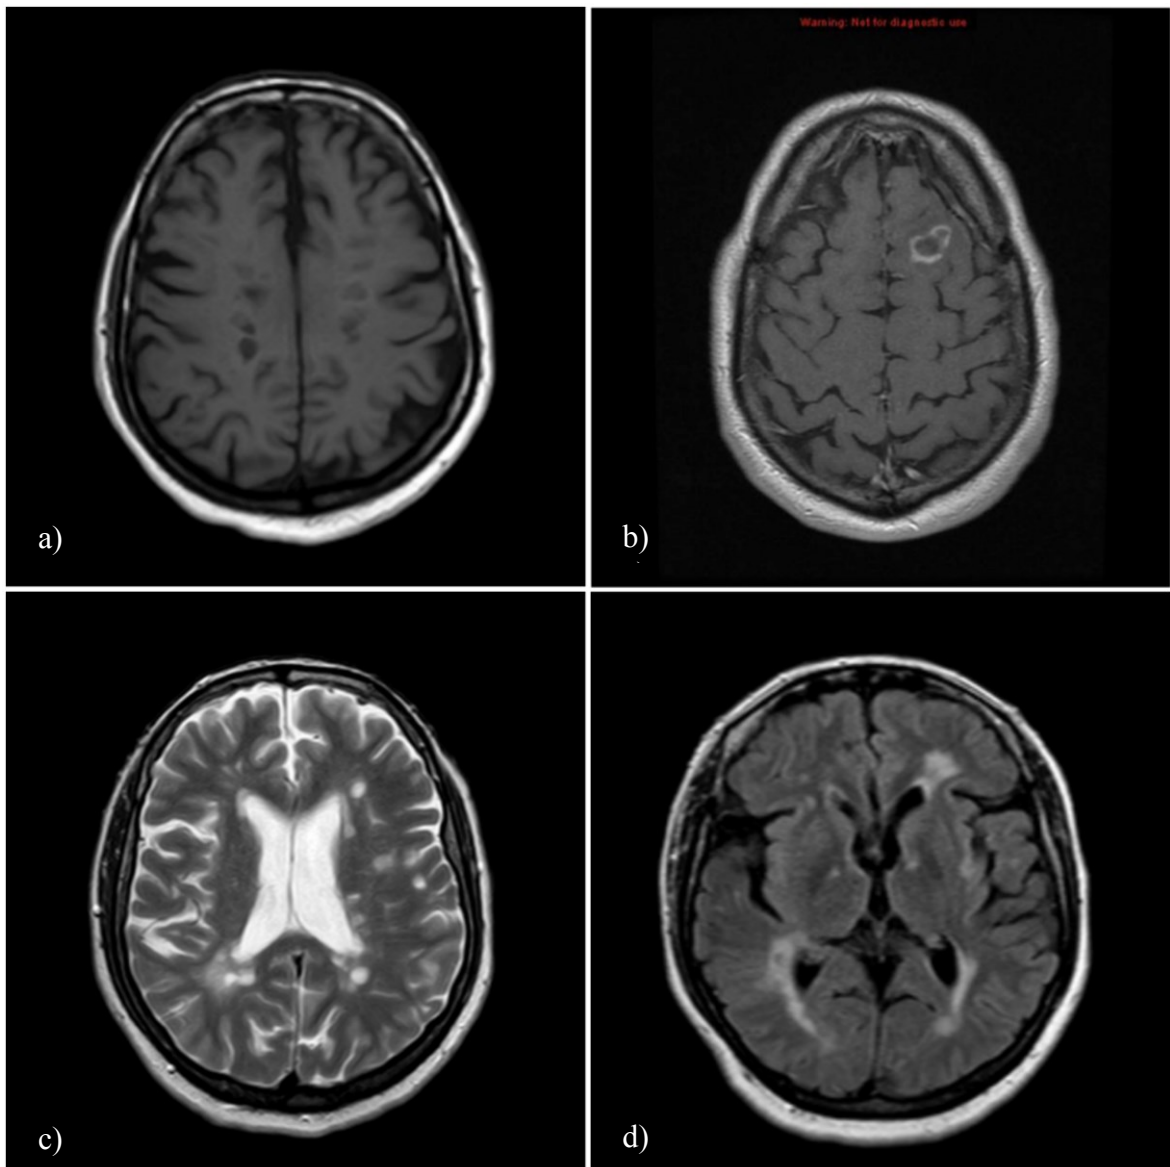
Example for conventional MRI sequences^{33,34}: a proportion of lesions on T1-weighted (a) sequences may appear hypointense, with added contrast-agents some show enhancement (here ring-enhancement) (b); on T2-weighted (c) and FLAIR (d) sequences lesions appear hyperintense
